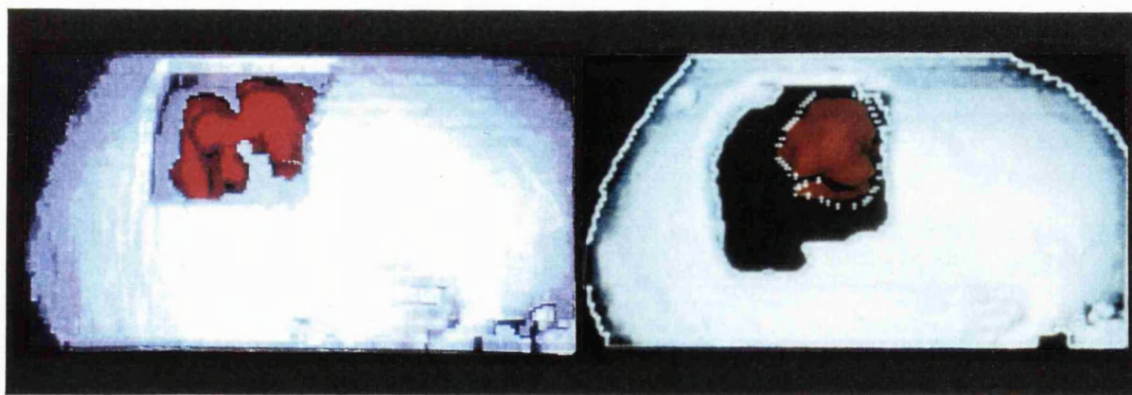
Case 7: a. Pre treatment PET volume in planning CT volume for craniotomy
